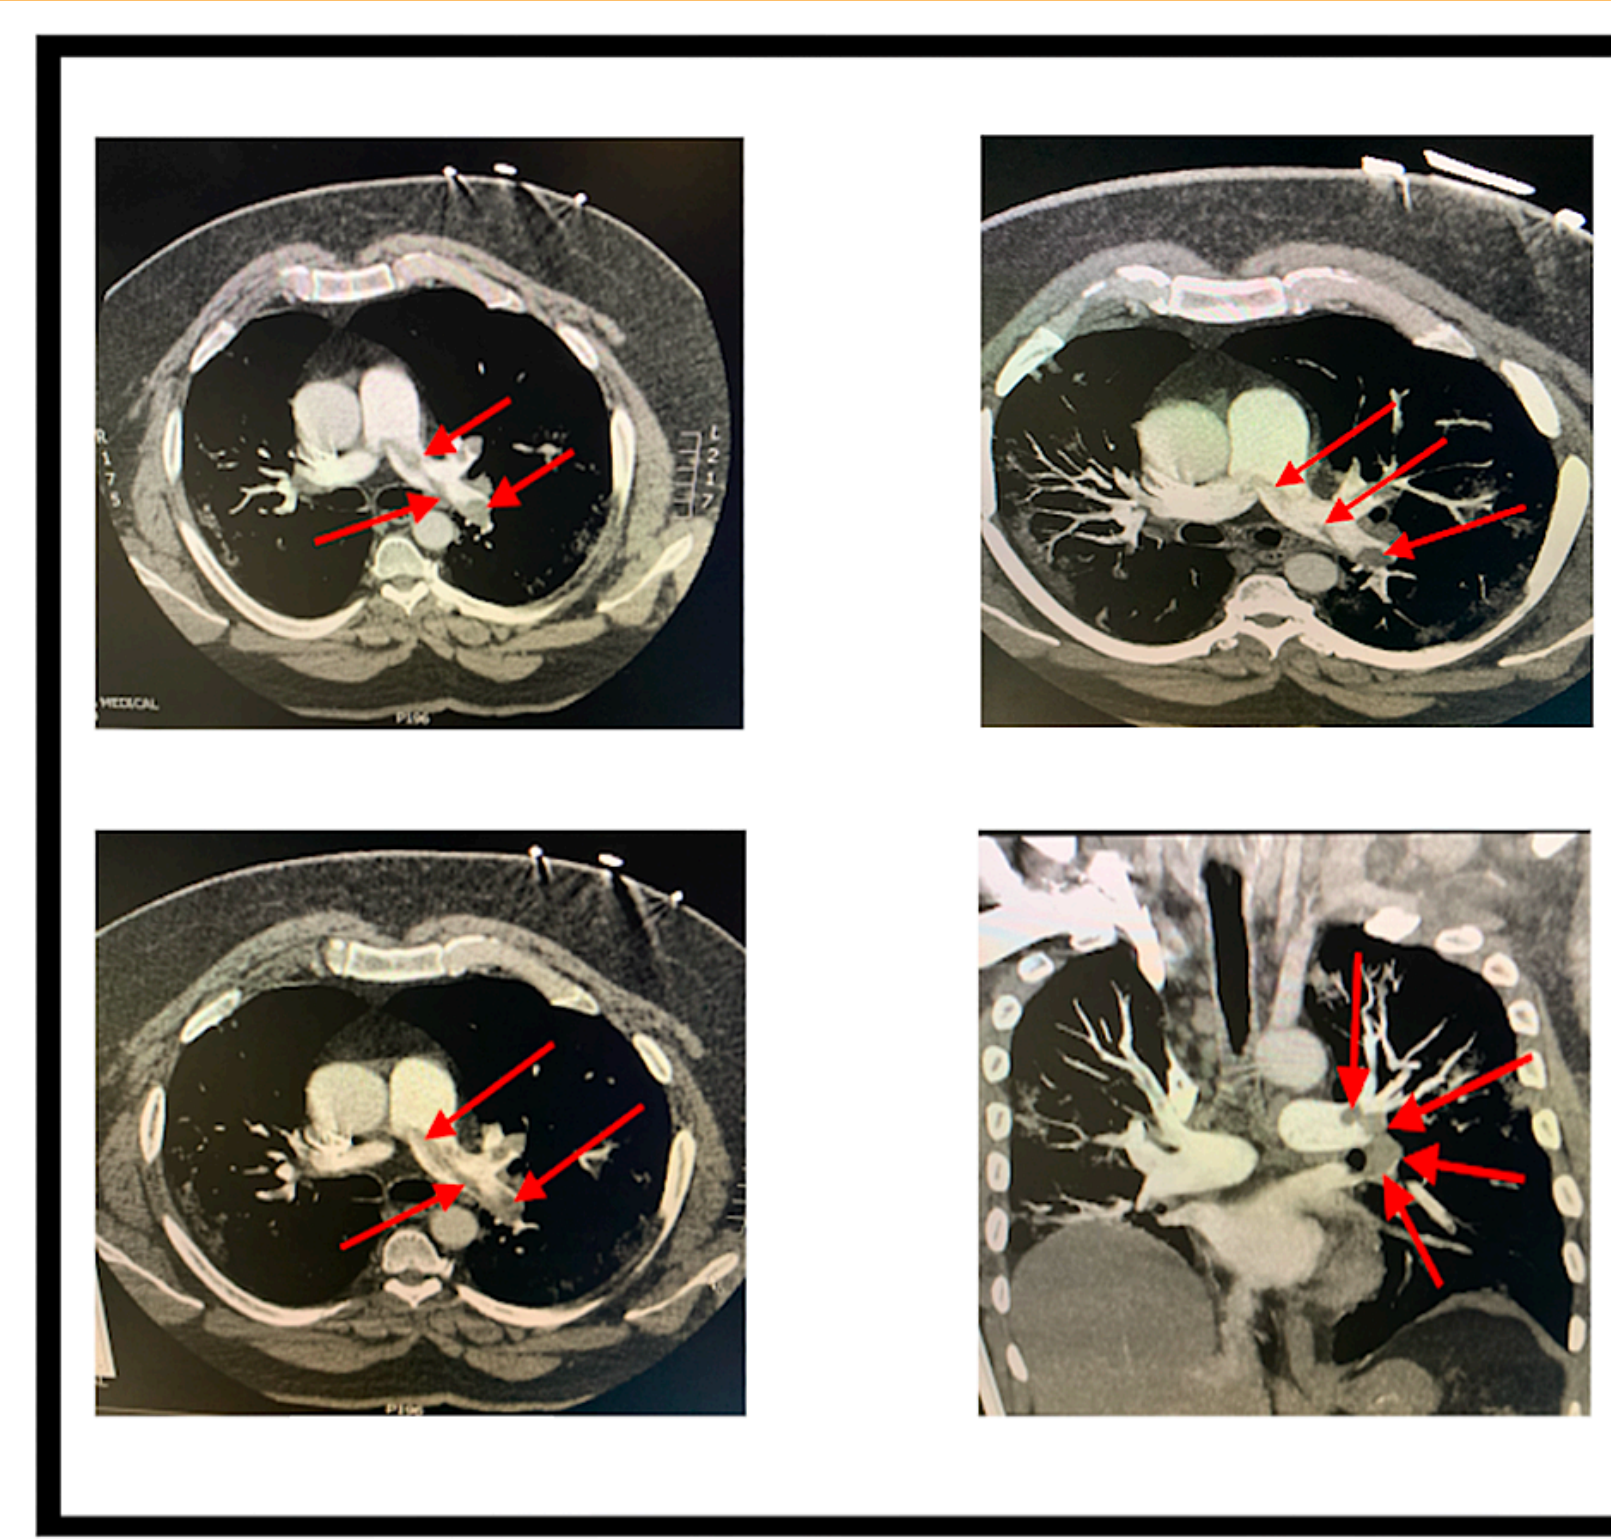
CT pulmonary angiography with coronal, sagittal, and maximum intensity projection (MIP) reconstructions. The images show thrombus crossing the bifurcation extending into the right upper, middle, and lower lobe segmental branches with a greater thrombus burden on the left pulmonary arteries (arrows).
